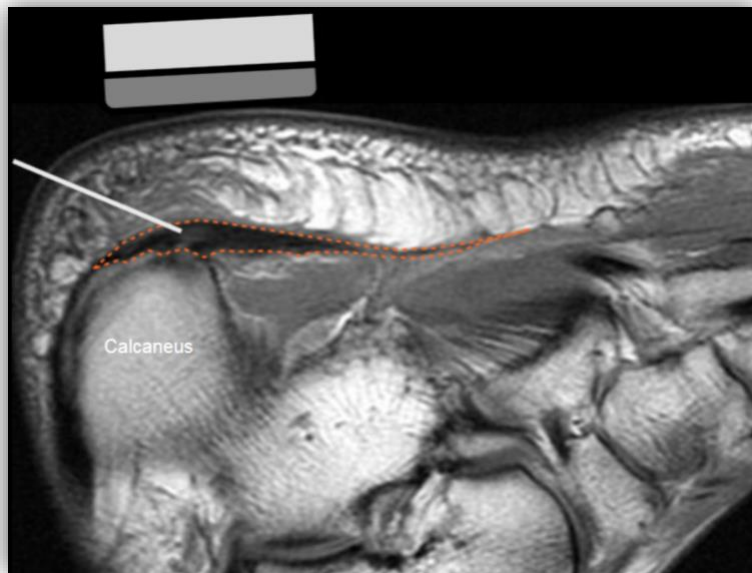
Sagittal T1-weighted MR image demonstrates proper transducer positioning and needle trajectory for injection at the plantar fascia (orange dashed outline).
